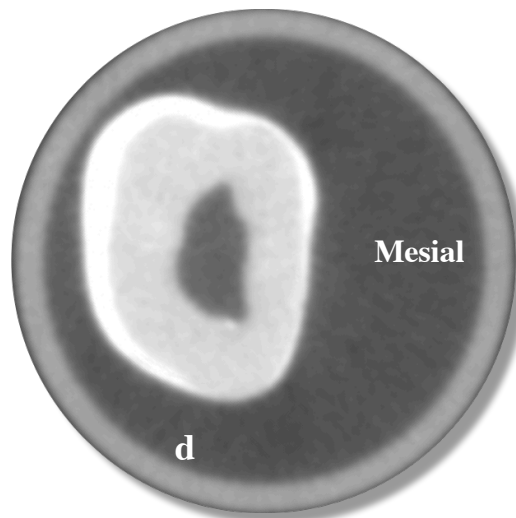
Maxillary 1st molar with a distal crack. Selected corresponding axial slices: SWIFT MRI (c) with a high-contrast appearance of the distal crack, and limited FOV CBCT (d) with low-contrast appearance of the same distal crack.
